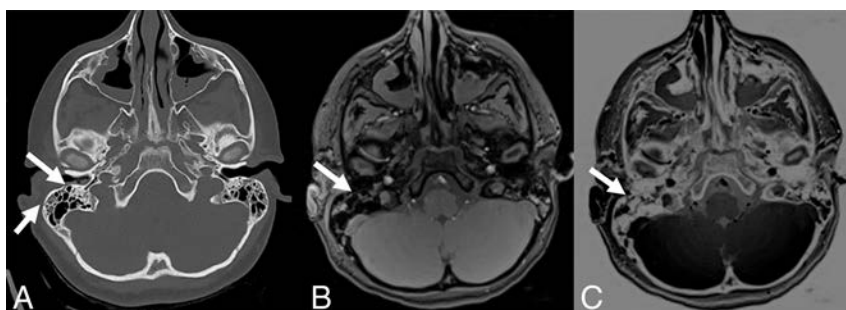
A, Axial CT image shows 2 small nondisplaced linear fractures of the mastoid (arrows). On black bone (B) and inverted black bone (C) MR images, these fractures are barely visible (arrows).
